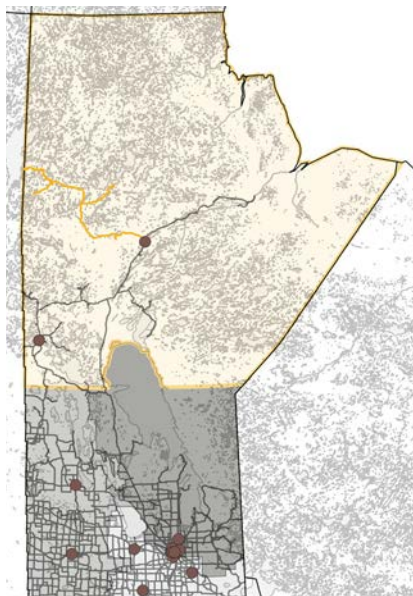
GIS map showing diagnostic imaging CT scanner locations.
